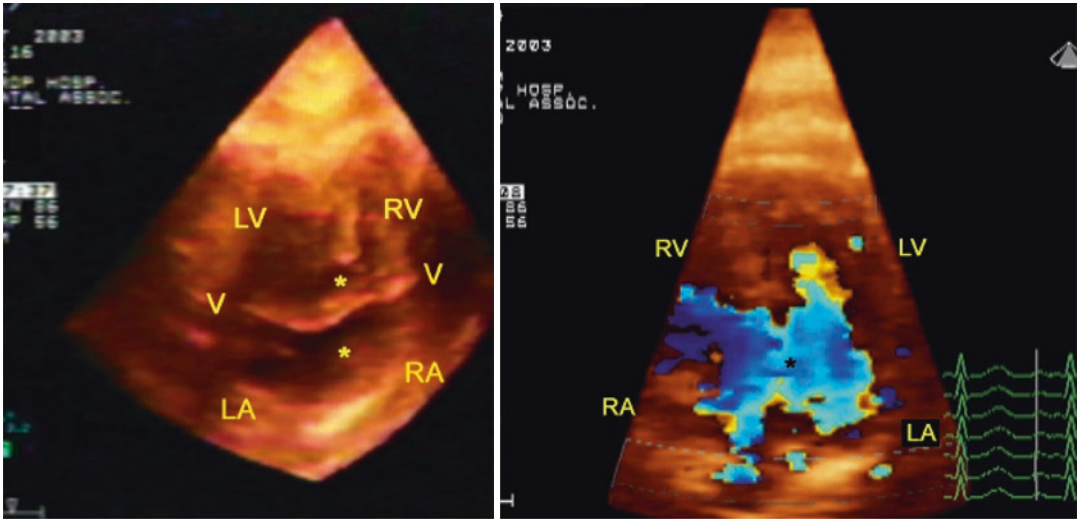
Four-dimensional echocardiography using a two-dimensional matrix phased array in a fetus with complete atrioventricular septal defect. Four-chamber view cropped to show the atrial and ventricular septal defect with common atrioventricular valve (left panel) and color
